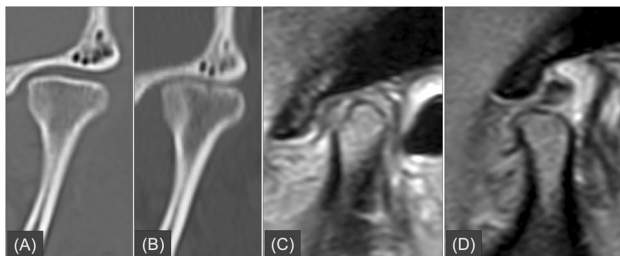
A The initial CT of a 35-year-old female with mandibular fractures at the right condylar base and left parasymphysis showed no evident bony deformity in the left TMJ. B The 12-month follow-up CT revealed left condylar head bony cortex erosion. A 9-month follow-up TMJ MRI showed significant thinning and suspected perforation in the intermediate zone of the left TMJ disc, as well as anterior disc displacement with reduction on closed-mouth (C) and open-mouth (D) sagittal proton density-weighted images
